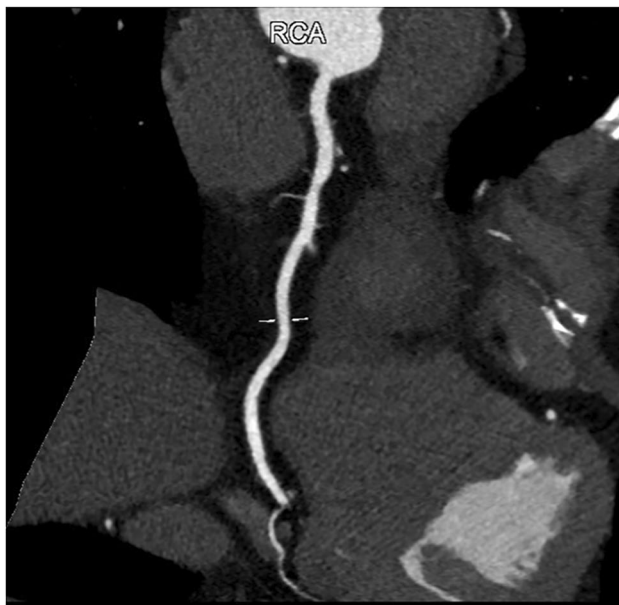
Photon-counting computed tomography 6 months before admission: 30% stenosis of RCA I
